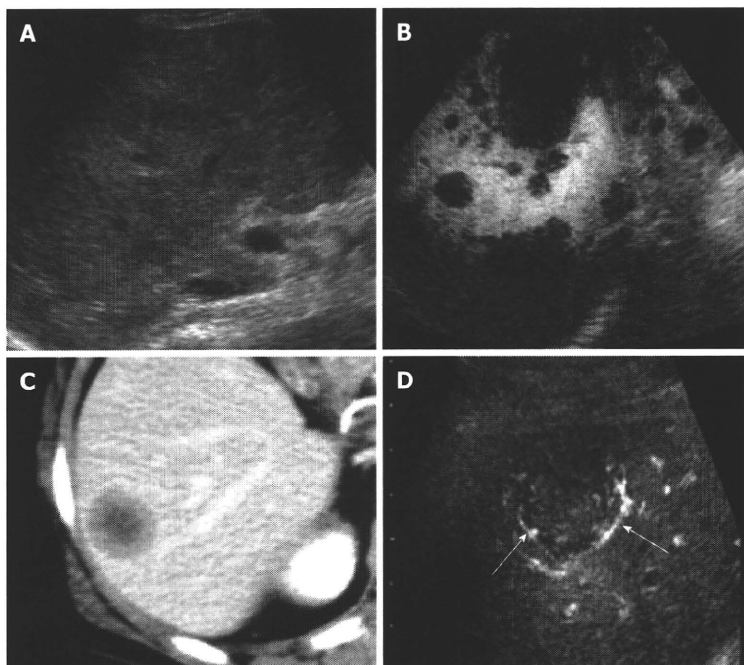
Liver metastasis. A: Multiple masses were seen in the liver by B-mode ultrasonography (US); B: Multiple defects were seen by Sonazoid-enhanced US in the post-vascular phase; C: Portal phase dynamic scan detected a hypoechoic nodule in segment 6 of the liver; D: Peripheral enhancement of the nodule (arrows) was obtained by Sonazoid-enhanced ultrasonography in the early vascular phase.
